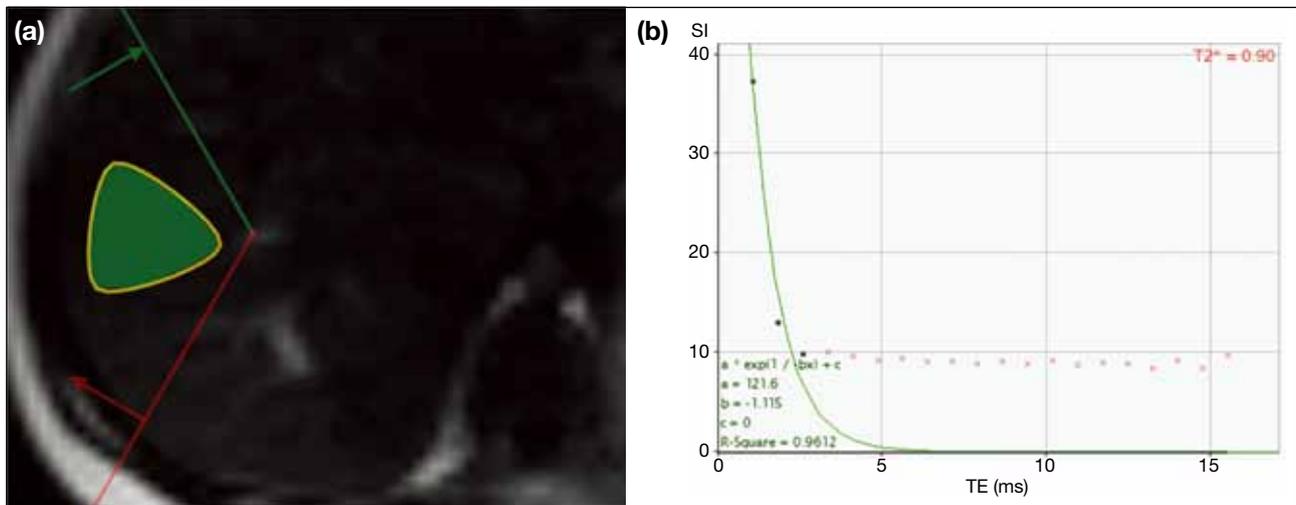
Magnetic resonance imaging assessment of hepatic T2* value: (a) Region of interest is drawn in the periphery of the right lobe of liver (highlighted in green), avoiding the hepatic and portal veins. (b) Data analysis using (CMR tools, Cardiovascular Imaging Solutions, London, UK): the signal intensity (TE) is plotted against multiple TE values (1.07, 1.83, 2.59, 3.35, 4.11, 4.87, 5.63, 6.39, 7.15, 7.91, 8.67, 9.43, 10.19, 10.95, 11.71, 12.47, 13.23, 13.99, 14.75, 15.51 ms). The exponential signal decay curve is then constructed. T2* value is calculated automatically by the preset formula. A T2* value of less than 1.4 indicates severe iron overload in the liver.
